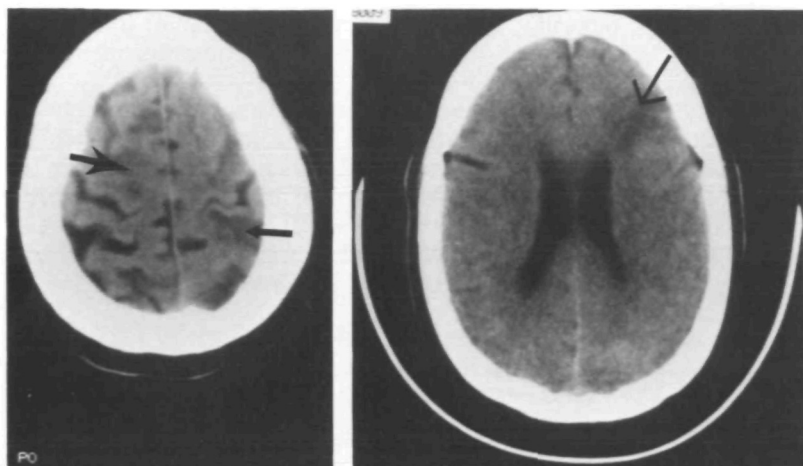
Cranial computed tomography showing right parasagittal (large bold arrow), left parietal (small bold arrow), and left frontal (large fine arrow) infarcts in 52-year-old hypertensive man with 80% stenosis of left internal carotid artery.
